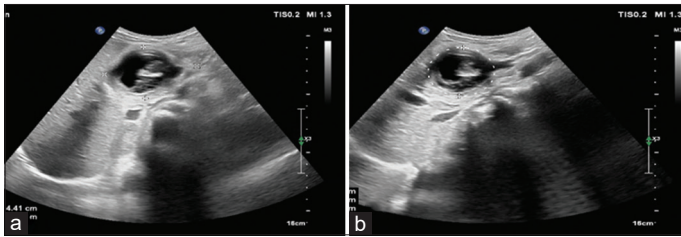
Ultrasonography of the pancreatic hydatid cyst. (a) transverse and (b) sagittal views of pancreatic head hydatid cyst showing well-defined anechoic cyst with internal free-floating membranes
